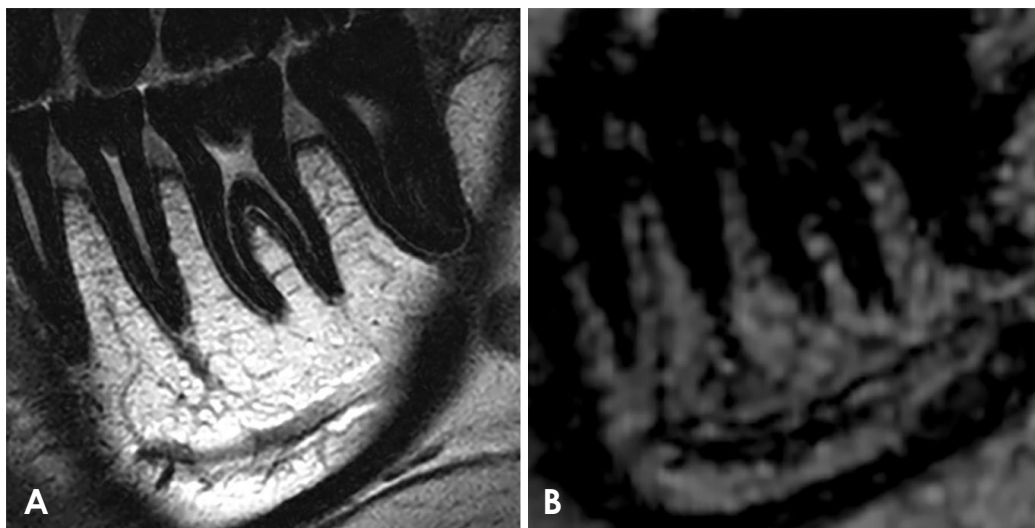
Images of a 20-year-old woman. A. 2-dimensional proton density-weighted image with visualization scores of over 4.0 for the tooth, root dental pulp, periodontal ligament, lamina dura, coronal dental pulp, gingiva, and nutrient tract (completely visible). The high-signal intensity area around the periapical root is consistent with the periodontal ligament. B. A 3D-eTHRIVE image with a visualization score of 2.0 in the nutrient tract (less than half visible), but 1.0 in the other structures (not at all visible). 3D-eTHRIVE: 3-dimensional T1-high resolution isotropic volume excitation.
